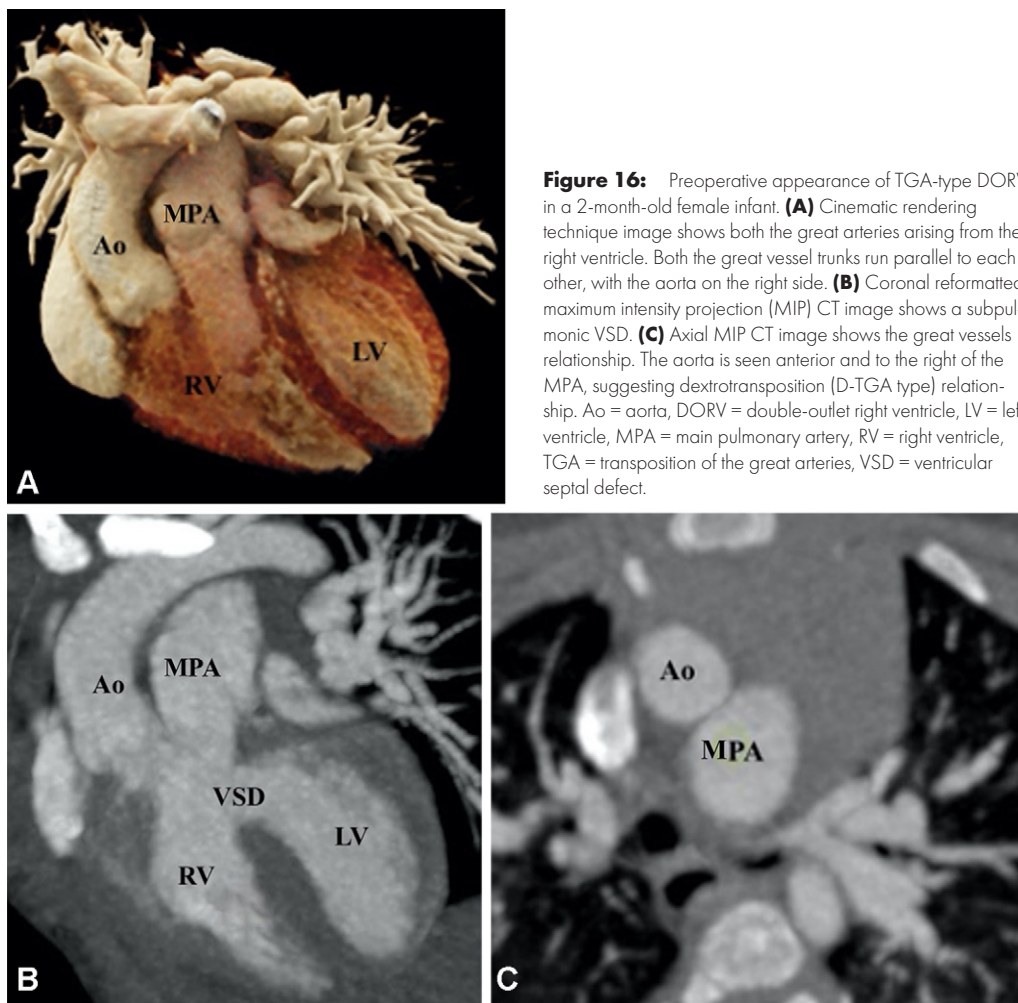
Preoperative appearance of TGA-type DORV in a 2-month-old female infant. (A) Cinematic rendering technique image shows both the great arteries arising from the right ventricle. Both the great vessel trunks run parallel to each other, with the aorta on the right side. (B) Coronal reformatted maximum intensity projection (MIP) CT image shows a subpulmonic VSD. (C) Axial MIP CT image shows the great vessels relationship. The aorta is seen anterior and to the right of the MPA, suggesting dextrotransposition (D-TGA type) relationship. Ao = aorta, DORV = double-outlet right ventricle, LV = left ventricle, MPA = main pulmonary artery, RV = right ventricle, TGA = transposition of the great arteries, VSD = ventricular septal defect.
